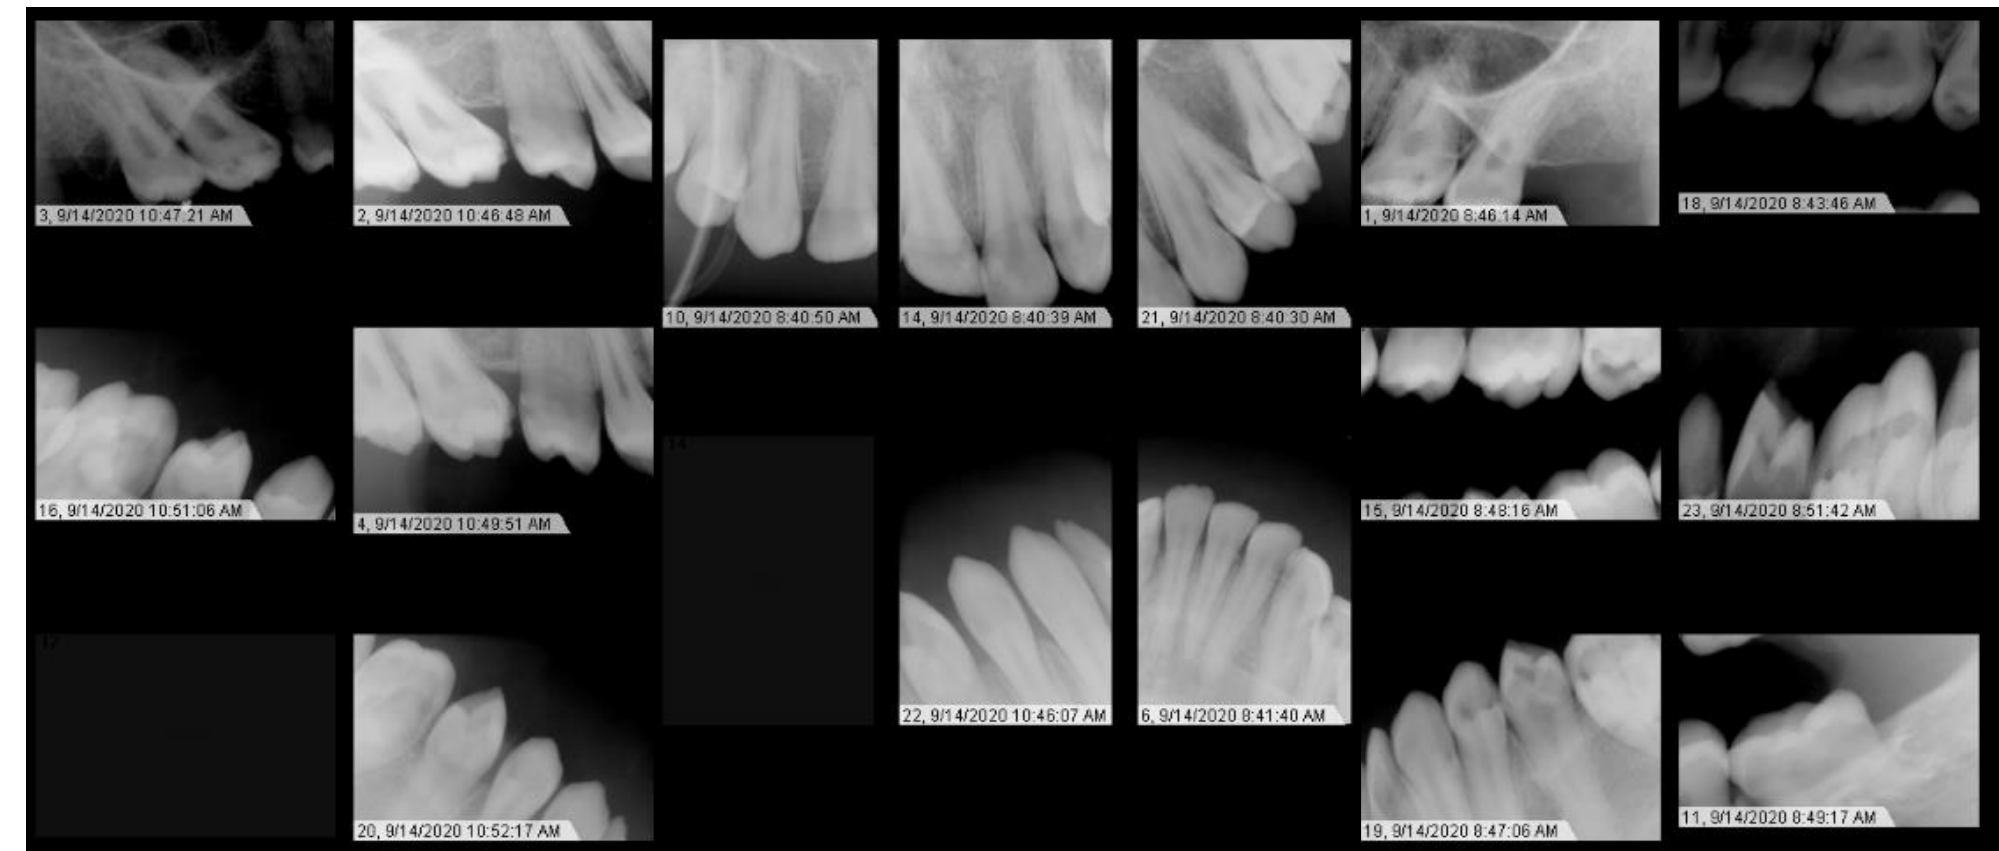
Intraoral and Panoramic Radiographs (2020) Caries and missing permanent teeth
